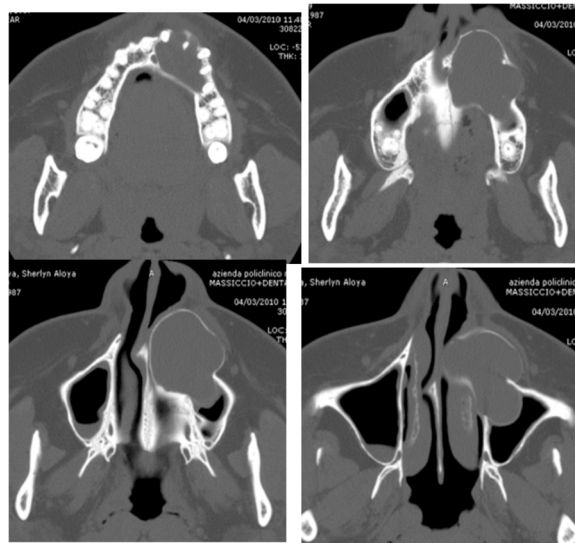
The axial computed tomography images show a radiopaque area involving the left upper maxilla alveolar process, the left maxillary sinus with the forward expansion of its anterior wall and the inferior meatus.
